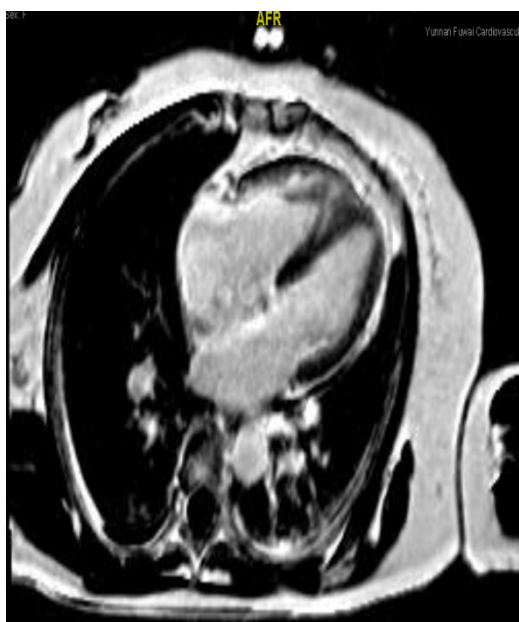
Cardiac MRI: The right ventricular diameter is full, with moderate to severe stenosis in the opening of some branches, particularly on the right side.
